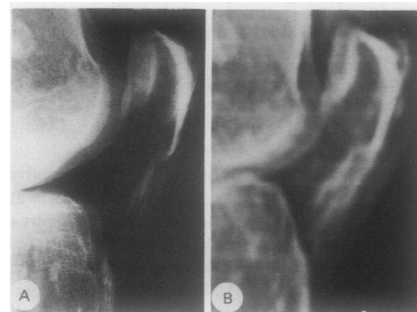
(A) Plain radiograph; (B) tomogram.
